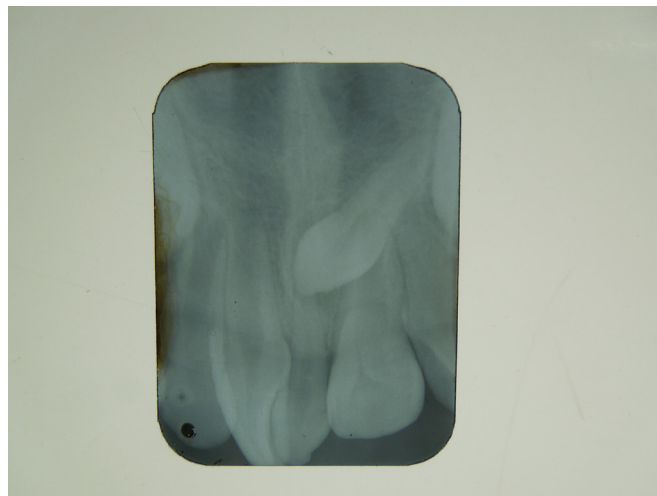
Intraoral periapical radiograph maxillary incisor region confirming presence of two supernumerary teeth.
